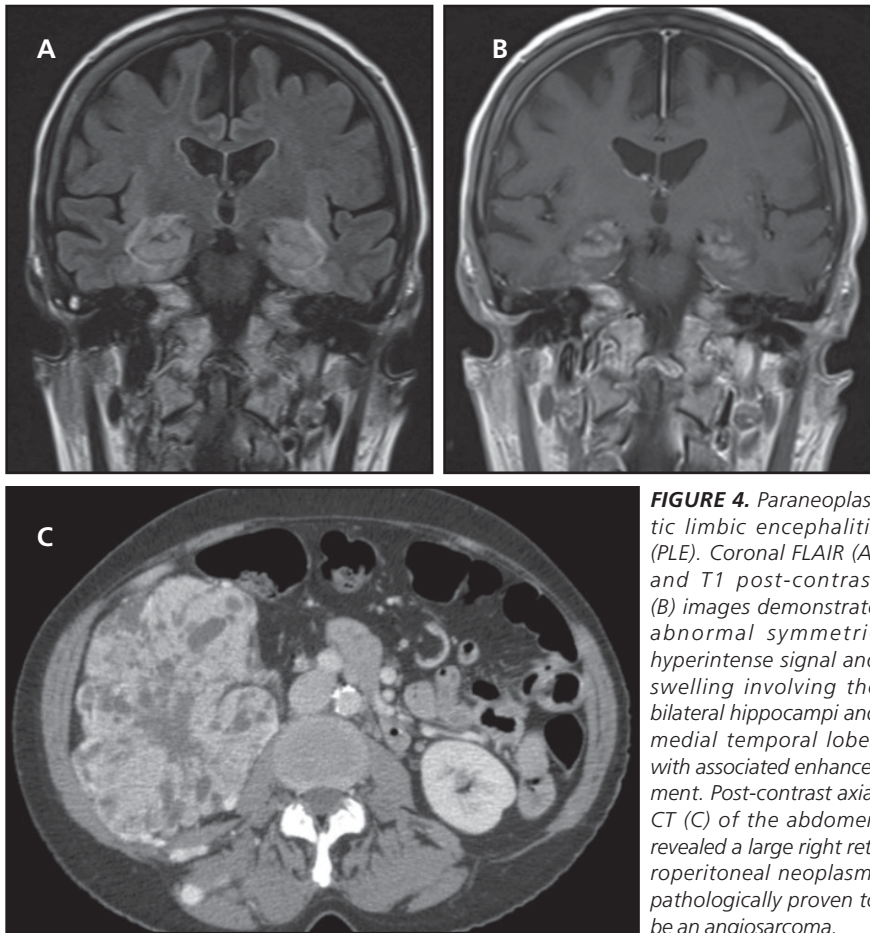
Paraneoplastic limbic encephalitis (PLE). Coronal FLAIR (A) and T1 post-contrast (B) images demonstrate abnormal symmetric hyperintense signal and swelling involving the bilateral hippocampi and medial temporal lobes with associated enhancement. Post-contrast axial CT (C) of the abdomen revealed a large right retroperitoneal neoplasm, pathologically proven to be an angiosarcoma.
